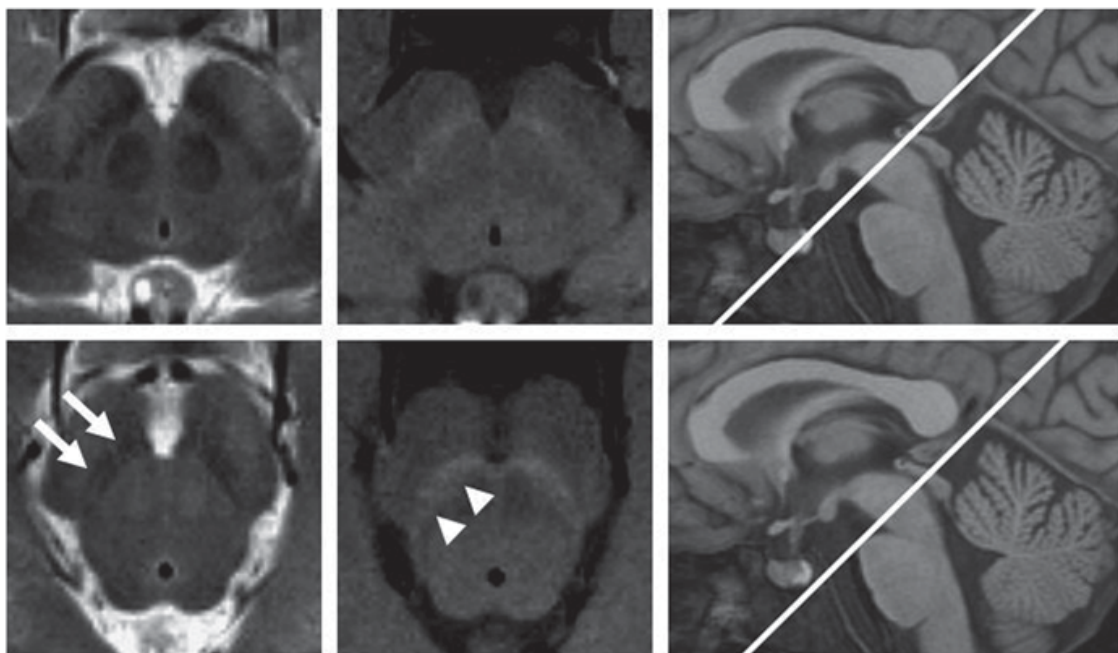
High in-plane resolution T2- and T1-weighted MRI of the mesencephalon. *Arrows* point to the iron-rich substantia nigra pars reticulata (SNr) appearing hypointense in T2-weighted images shown in the *left* column. *Arrow heads* depict the neuromelanin-containing substantia nigra pars compacta (SNc) appearing hyperintense in T1-weighted images shown in the *middle* column. Images on the *right side* depict slice positions. (Siemens Trio, $B_0=2.9$ T, 8 channel head coil, turbo spin echo, echo train length 3, 2.0-mm slice thickness, 0.6×0.6 mm² in-plane resolution, no gap, FoV=192 mm, 320×320 matrix; T2 weighting: TE=117 ms, TR=3 s, three averages; T1 weighting: TE=10 ms, TR=675 ms, eight averages). *VTA* ventral tegmental area, *TE* echo time, *TR* repetition time, *FoV* field of view
